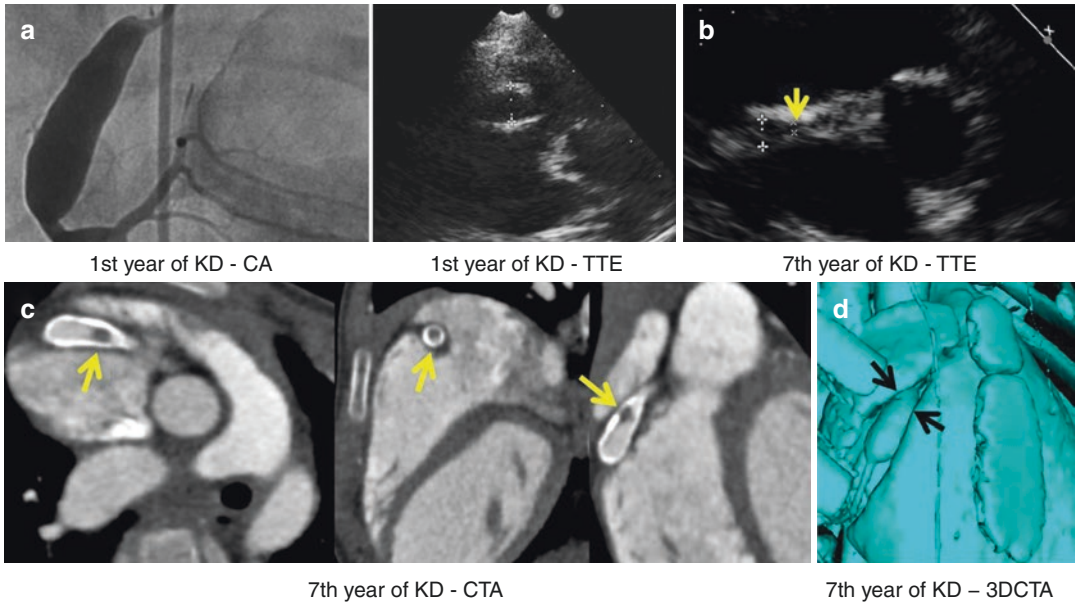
A 7-year-old girl was admitted to our institution due to “ongoing stenosis” within a large fusiform RCA aneurysm revealed by coronary CTA after TTE showed a “regression” over proximal segment of RCA aneurysm (a). Left anterior oblique view of selective CA and corresponding TTE after first year of KD (b) TTE showed
